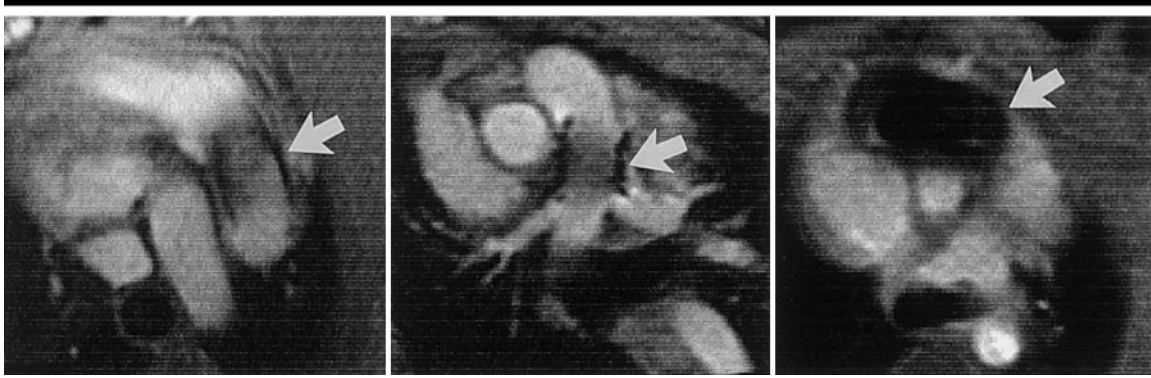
Cine MR images (8/3; flip angle, 20°; section thickness, 10 mm) acquired through longitudinal midportion of Memotherm nitinol stent (left), NuMed platinum stent (center), and elgiloy Wallstent (right) 3 months after stent placement in main pulmonary artery. Susceptibility artifacts (arrow) were less pronounced with nitinol and platinum stents and were severe with Wallstents, which caused severe image distortion due to the artifacts.
